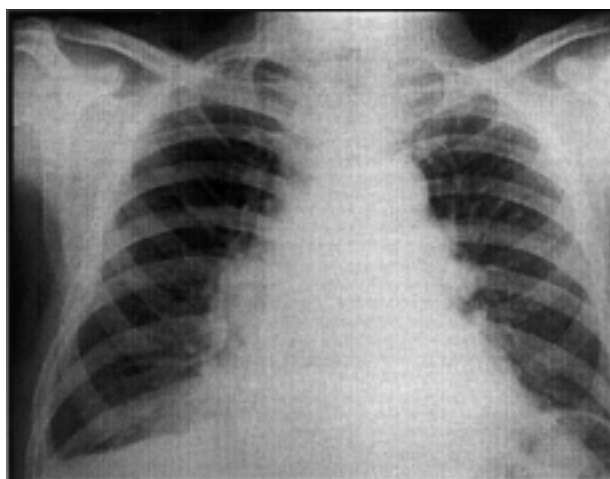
Chest X-ray film. Note the cardiomegaly, ectasia of the aorta, the diffusely vascular accentuation of the pulmonary fields and, on the right side, the outcomes of a previous pleurisy.
